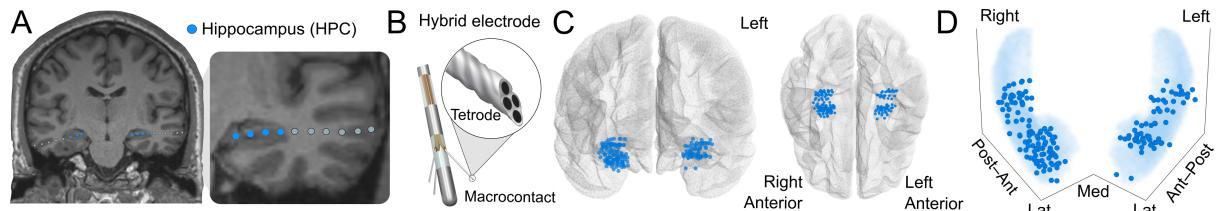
Direct electrophysiological recordings from the human hippocampus (A) T1-weighted MRI showing contact locations from two representative depth electrodes targeting the hippocampus. (B) Each hybrid electrode incorporated tetrodes extending from the macrocontact shaft. (C and D) MNI template brain and 3D projection showing hippocampal electrode contact locations across participants (axes: Post–Ant, posterior–anterior; Med–Lat, medio–lateral; Sup–Inf, superior–inferior).
